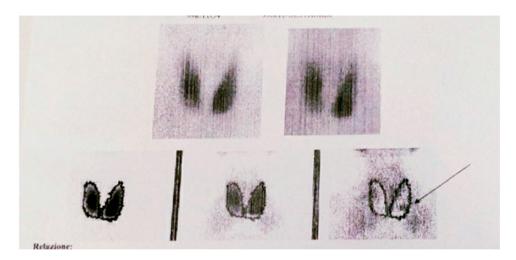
99-Tc-sestamibi scintigraphy image, showing a hyperfunctioning adenoma of the left inferior parathyroid.
